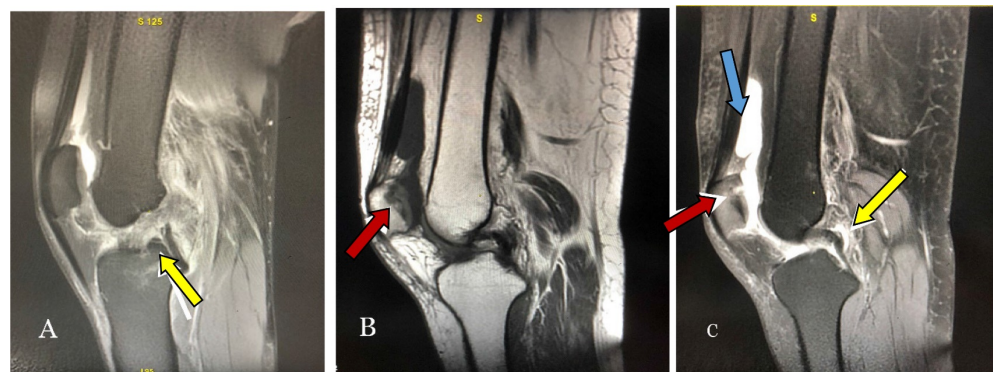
MRI images of the knee in sagittal sections, T2 sequence passing through the ruptured anterior cruciate ligament marked with a yellow arrow (A), T1 sequence (B) and T2 (C) sequences passing through the patella showing stage 4 chondropathy (red arrow B and C) with subchondral geodes and intra-articular effusion in hypo signal T1 and hyper signal T2 (C: blue arrow). Ruptured posterior cruciate ligament (C: yellow arrow).
